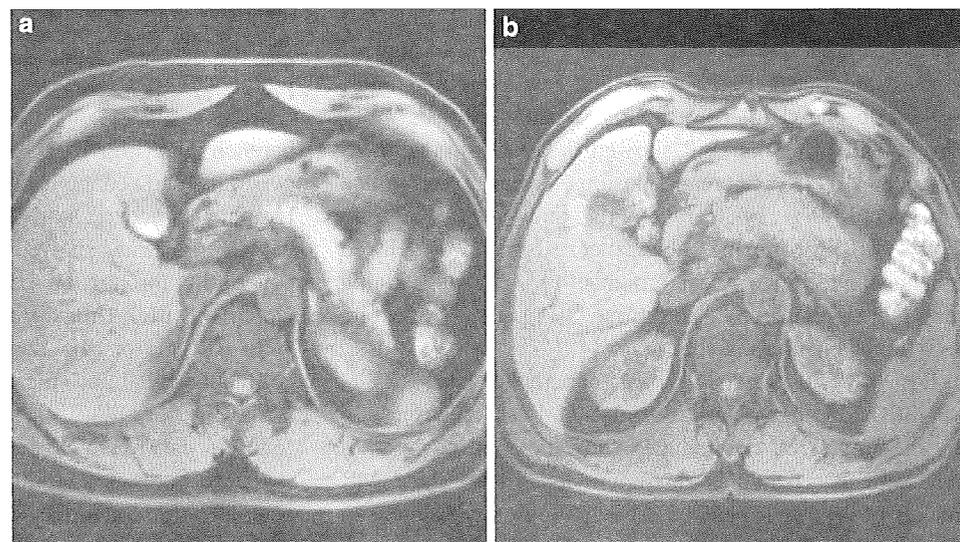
a Contrast-enhanced CT of AIP shows a localized mass lesion in the pancreatic head in the early phase. b In the late phase, delayed homogeneous enhancement was seen in the mass lesion
